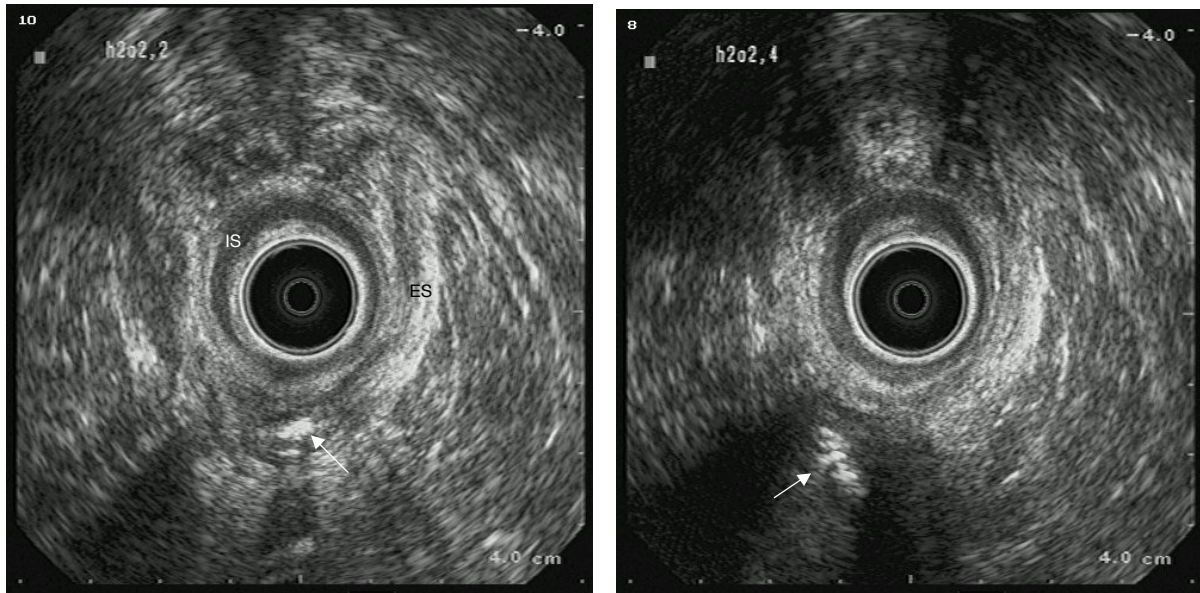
Transanal ultrasonography with peroxide introduced via the external fistula opening in patient 7 showing a transsphincteric fistula (arrow left picture) with a supralevator extension (arrow right picture). IS internal sphincter; ES external sphincter.
